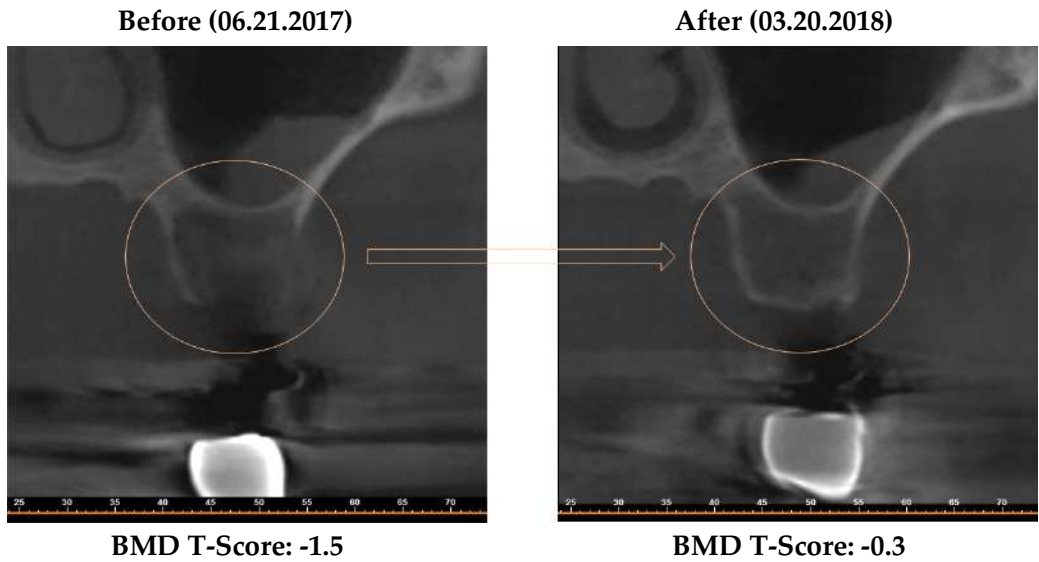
The X-Ray Image for an Asian Male Who is 58 Years Old Showed Dental Bone Growth After treating AIC for 10 Months without any Cotreatment. (The T-Score for the Dental Bone is Significantly Improved)
